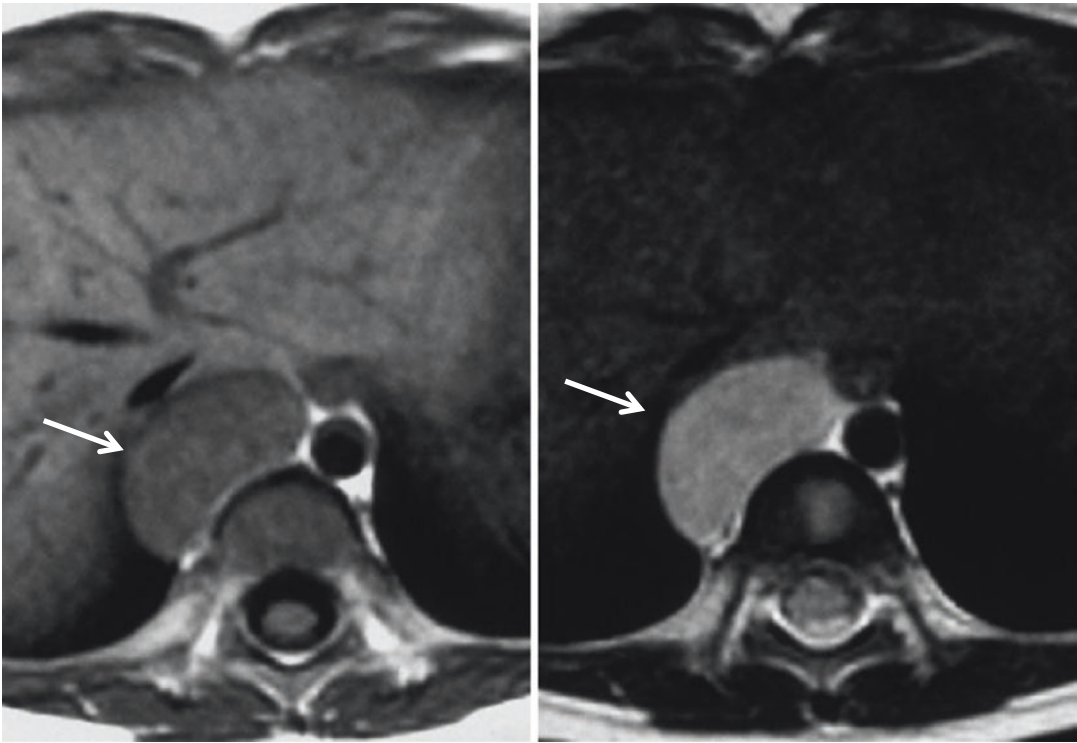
Ganglioneuroblastoma. A right paravertebral mass shows low signal intensity on T1-weighted image (a) and high signal intensity on T2-weighted image (b) (arrows). Ganglion cell tumor typically arises in the anterior paravertebral region
